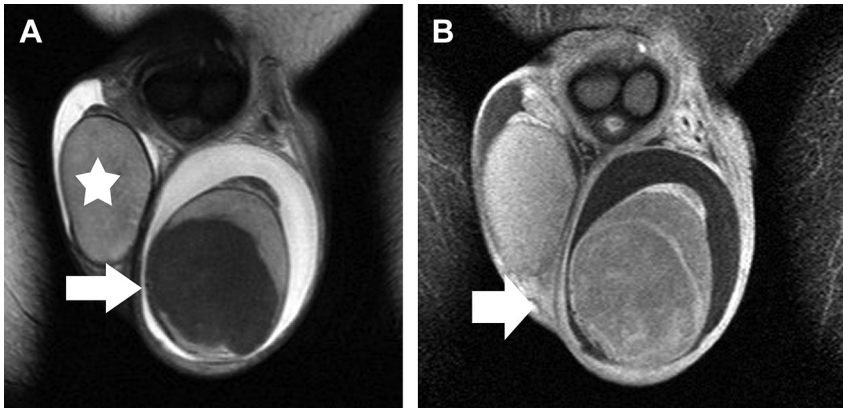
Primary diffuse large B-cell testicular lymphoma in a 52-year-old man. Coronal (A) T2- and (B) contrast-enhanced T1-weighted images depict large left intratesticular mass lesion (arrow). The tumor is mainly hypointense on T2-weighted images, when compared with the normal contralateral testis (asterisk, A) and enhances heterogeneously. A moderate left hydrocele and a small right hydrocele are also noted.
